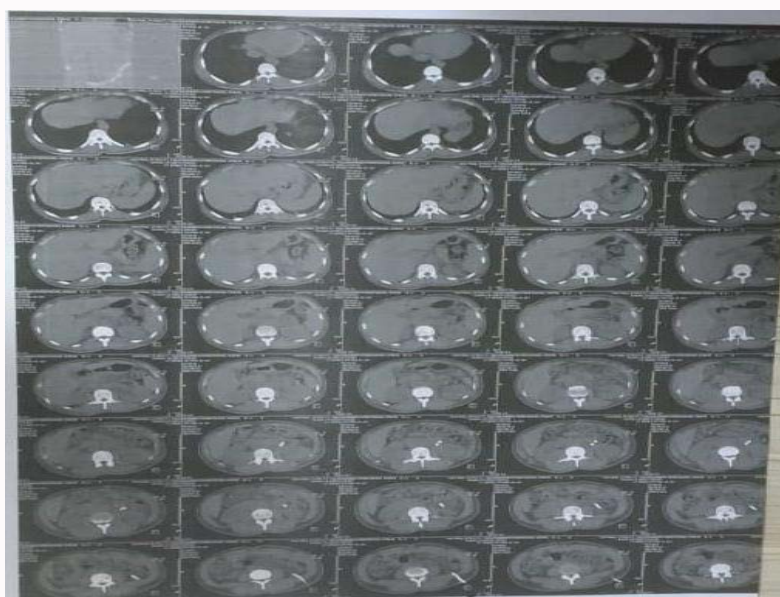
CT of abdomen with drainage catheter.
